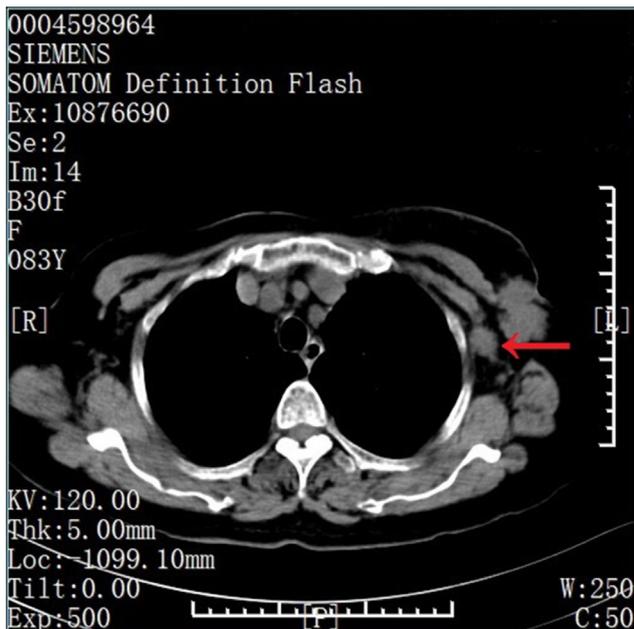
CT plain scan. The lymph node is round, with the increased volume and rough edges, shown with arrow.
